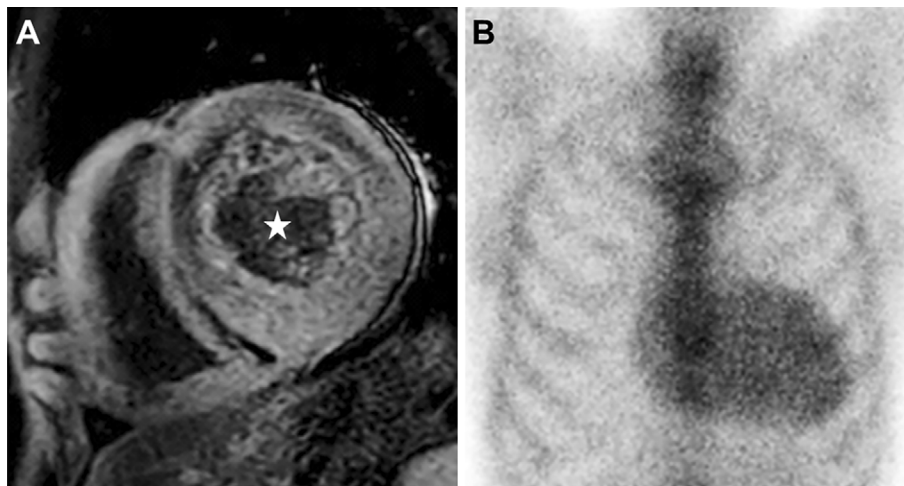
A: Late gadolinium-enhanced cardiac magnetic resonance imaging. Characteristic global subendocardial and transmural pattern of myocardial late gadolinium enhancement is shown in the thickened wall of both ventricles, since the contrast agent distributed to the extracellular space expanded by amyloid infiltration. Note that, in cardiac amyloidosis, the blood pool is abnormally dark (white star), possibly reflecting fast blood pool washout of the contrast media. B: The ^{99m}Tc -pyrophosphate scintigraphic findings. Diffuse cardiac accumulation of ^{99m}Tc -pyrophosphate was observed.
